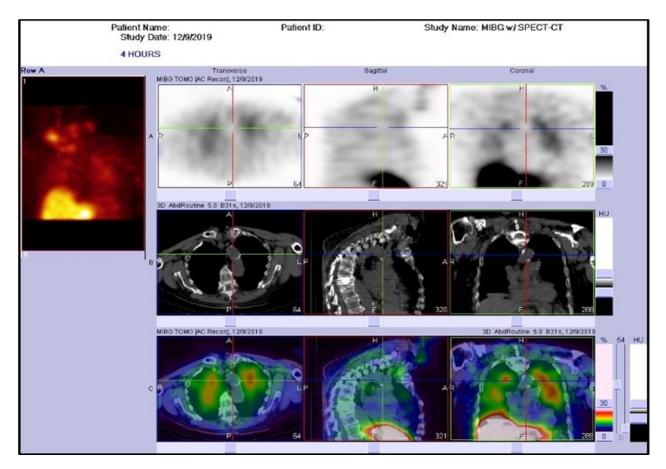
SPECT-CT image of the mediastinum at 4 hours
